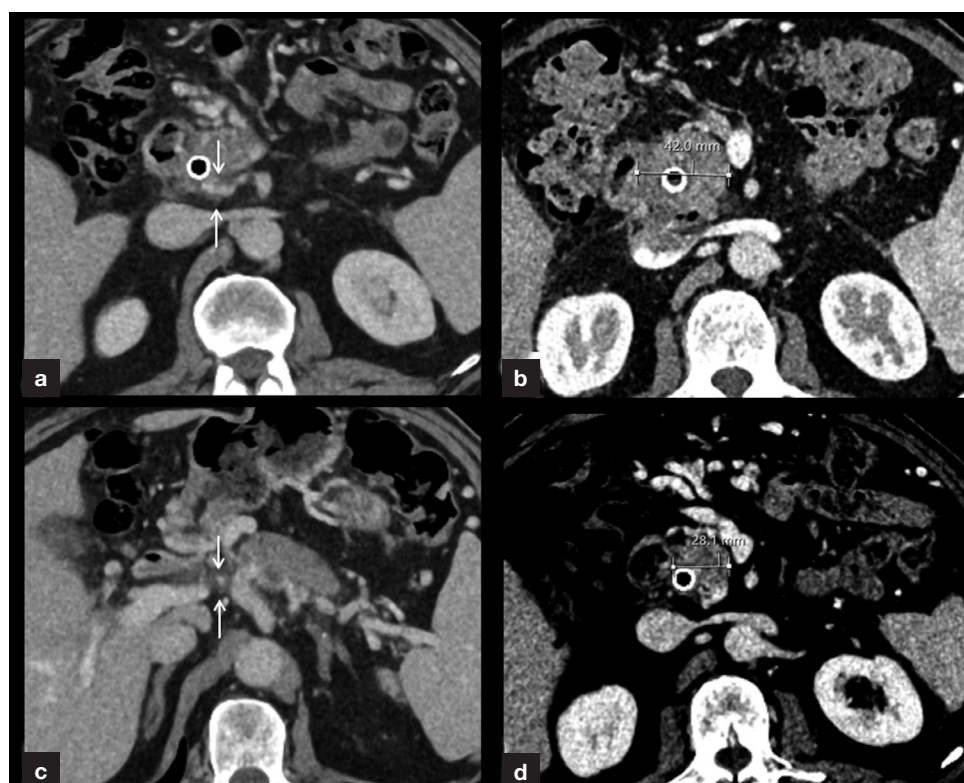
Pancreatic adenocarcinoma with arterial abutment of the common hepatic artery, pre- and post-neoadjuvant chemotherapy. a. Axial post-contrast computed tomography image shows tumour tissue surrounding the common hepatic artery (arrows). b. Axial image at a higher level shows a hypodense mass in the head of the pancreas around a metallic biliary stent. c. Post-treatment computed tomography shows persistent, but less, soft tissue around common hepatic artery (arrows); this was found to be fibrous tissue on trial resection. d. There is reduction in the size of tumour indicating response to treatment.
